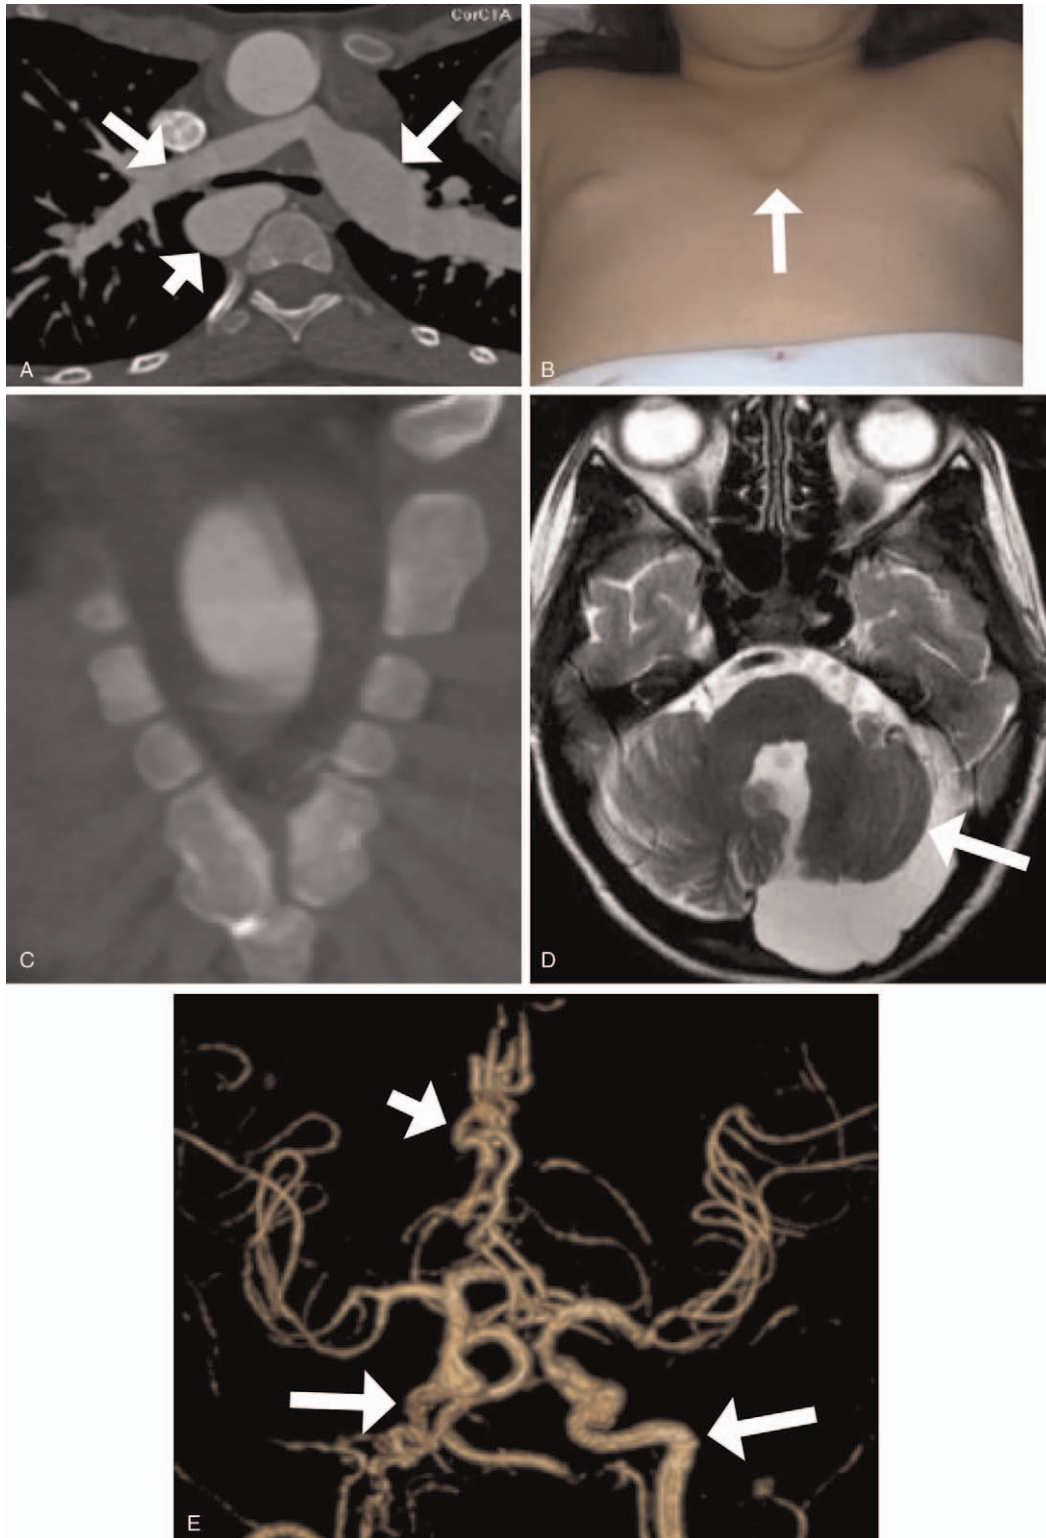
Young female child with PHACES syndrome. Axial contrast-enhanced CT (A) shows right aortic arch (short white arrow) associated with asymmetric pulmonary arteries (long white arrows) secondary to tricuspid atresia. Sternal cleft (B and C). Axial T2-weighted image (D) shows hypoplasia of the left cerebellar hemisphere associated with mega cisterna magna (white arrow). 3D image from MR angiography (E) shows ectasia of the anterior cerebral arteries (short white arrow) associated with dysplasia of the internal carotid arteries (long white arrows).
